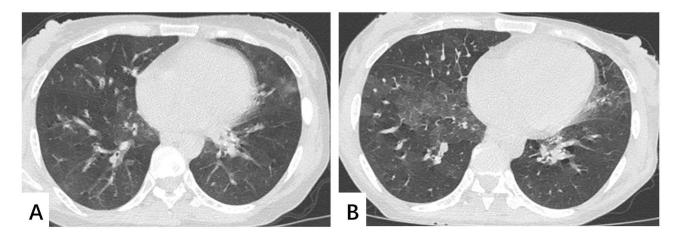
Figure I Lung computed tomography (CT) images. (A) Bilateral lungs show multiple ground-glass opacities, accompanied by partial thickening of the interlobular septa and bronchial wall thickening. (B) Bilateral lungs display multiple ground-glass opacities, with some interlobular septa thickening, showing progression compared to (A).
